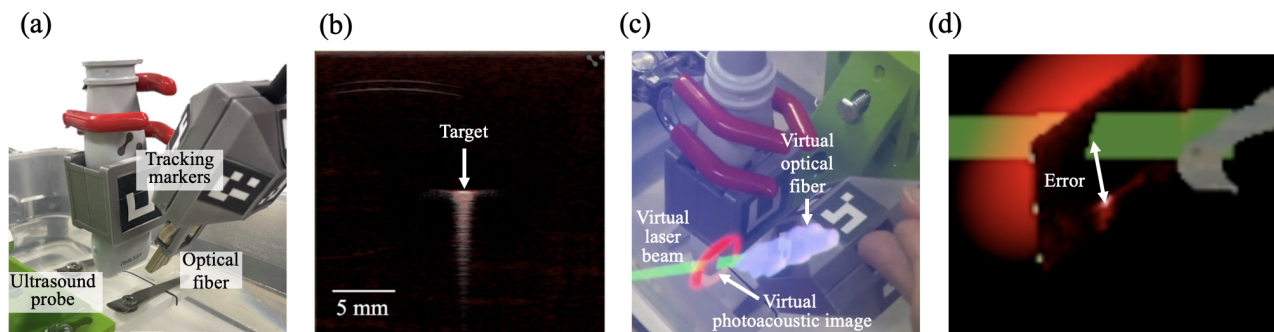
(a) Experimental setup with fixed ultrasound transducer and handheld laser, each tracked with custom ArUco markers. (b) Co-registered photoacoustic and ultrasound images displaying target signal at the imaging plane center. (c) Augmented reality user view showing virtual laser beam (green) intersecting virtual image plane (red) with live photoacoustic image overlay. (d) Demonstration of the error calculation, defined as the Euclidean distance between the intersection of the virtual laser with the virtual image plane and the center of the virtual image plane.
